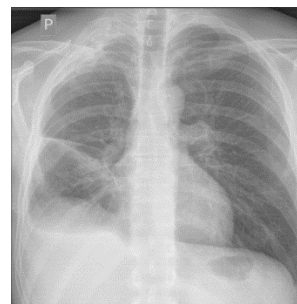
Chest X-ray obtained in the 21st day after accident, revealing a fully expanded lung and removed bullet from the chest wall
